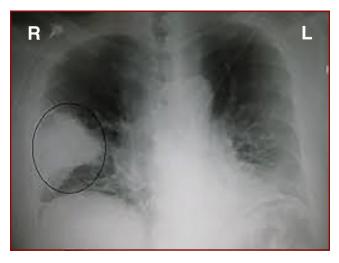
Standard x-ray shows area of infiltrate in the lower right lobe of the lung. In the figure, evidence of pneumonia can be seen on the right lower lobe of the lung.
